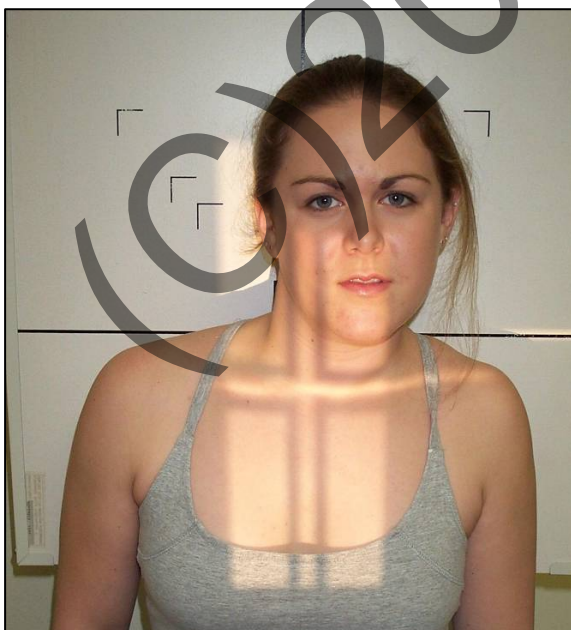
AP cervicothoracic radiographs are obtained with the patient sitting/standing with his/her shoulders centered against the cabinet. A 10x12 in. cassette is generally used with central ray at the mid-lower cervicals and for visualization of the upper thoracic spine.¹² If mid thoracic spine down to T6/7 is needed then it can be taken on a 7x17 in. cassette as depicted. This increased visualization of the upper thoracic spine is to see possible thoracic compensation due to cervical spine abnormalities. The patient positioning should be accomplished through small movements of the patient's feet and NOT by altering the patient's posture.²
